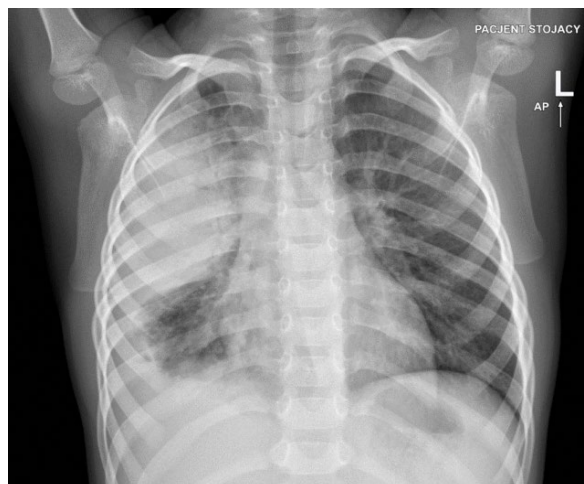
Chest X-ray on day 2 of hospital stay
